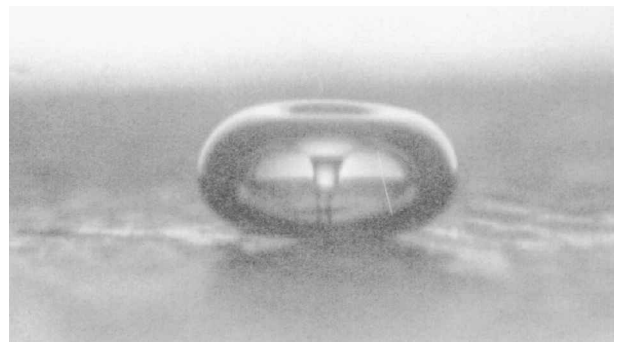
Formation of a microjet during the collapse of a free gas bubble close to a boundary. Reproduced with permission from Coleman *et al.* [135] (© 1987 World Federation of Ultrasound in Medicine and Biology)
